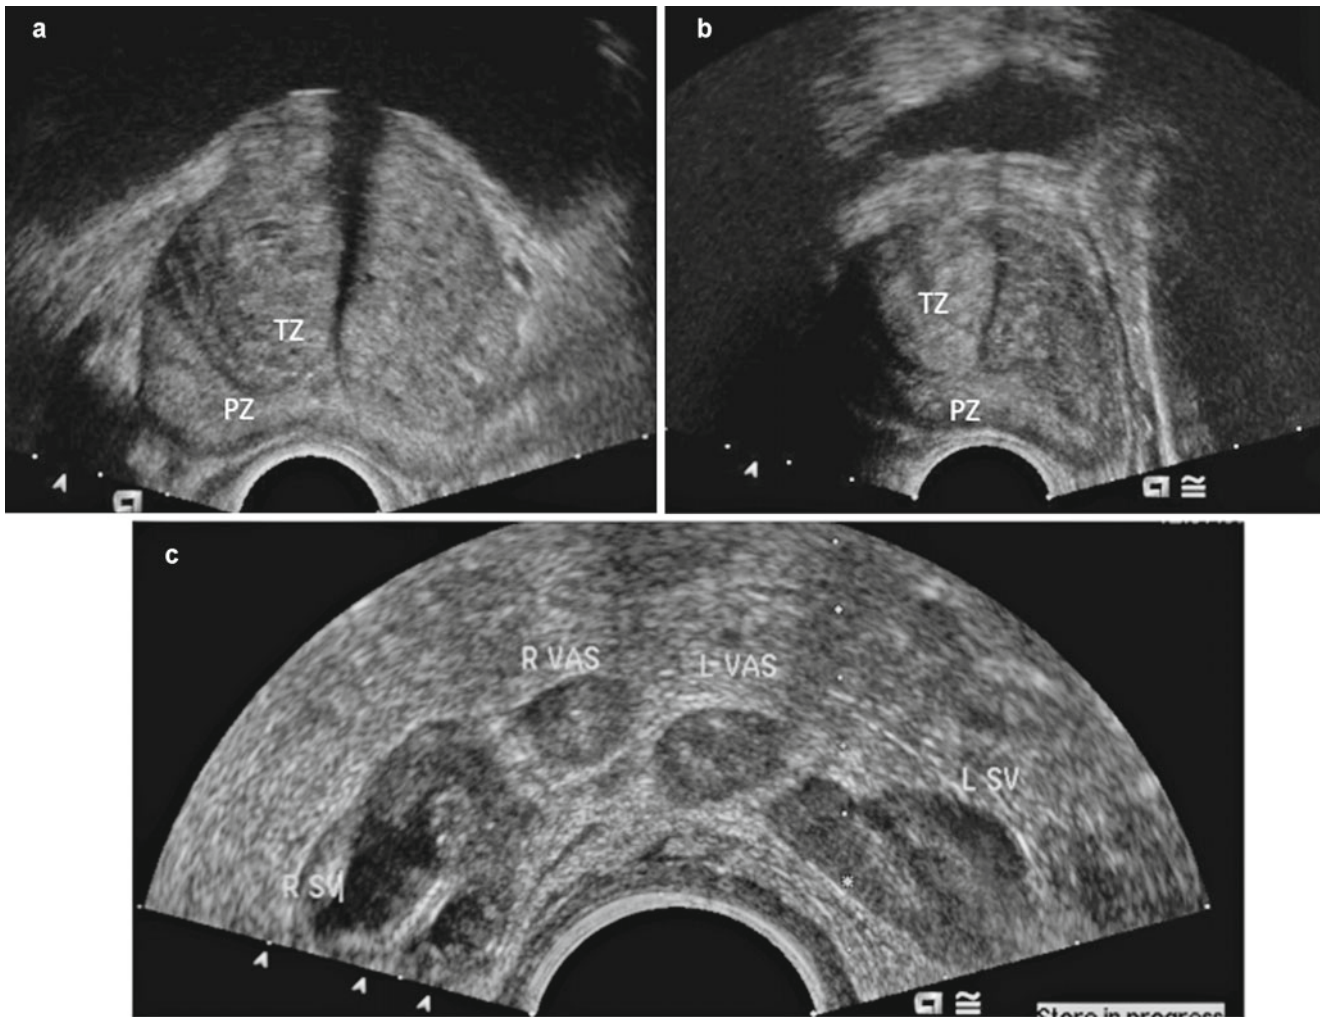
Transrectal ultrasound images of the prostate. (a) Transverse view. (b) Sagittal view. (c) At the level of the seminal vesicles (SV) and vas deferens (vas). TZ transition zone, PZ peripheral zone, R right, L left
